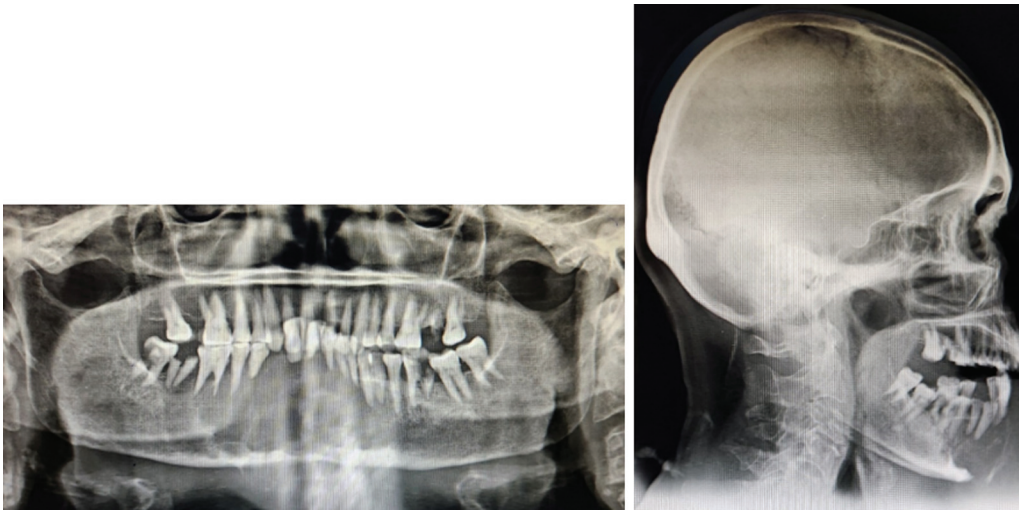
Orthopantomogram and lateral skull radiograph.
